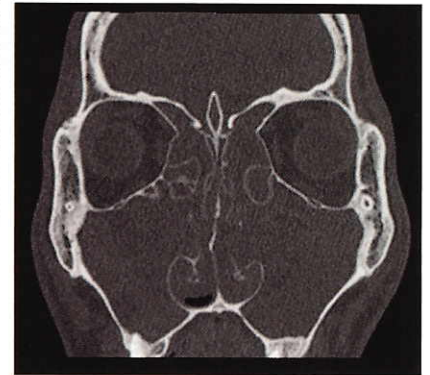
CT scan of the same patient (in fig 1b) showing complete opacification of the ethmoid and maxillary sinuses bilaterally.
